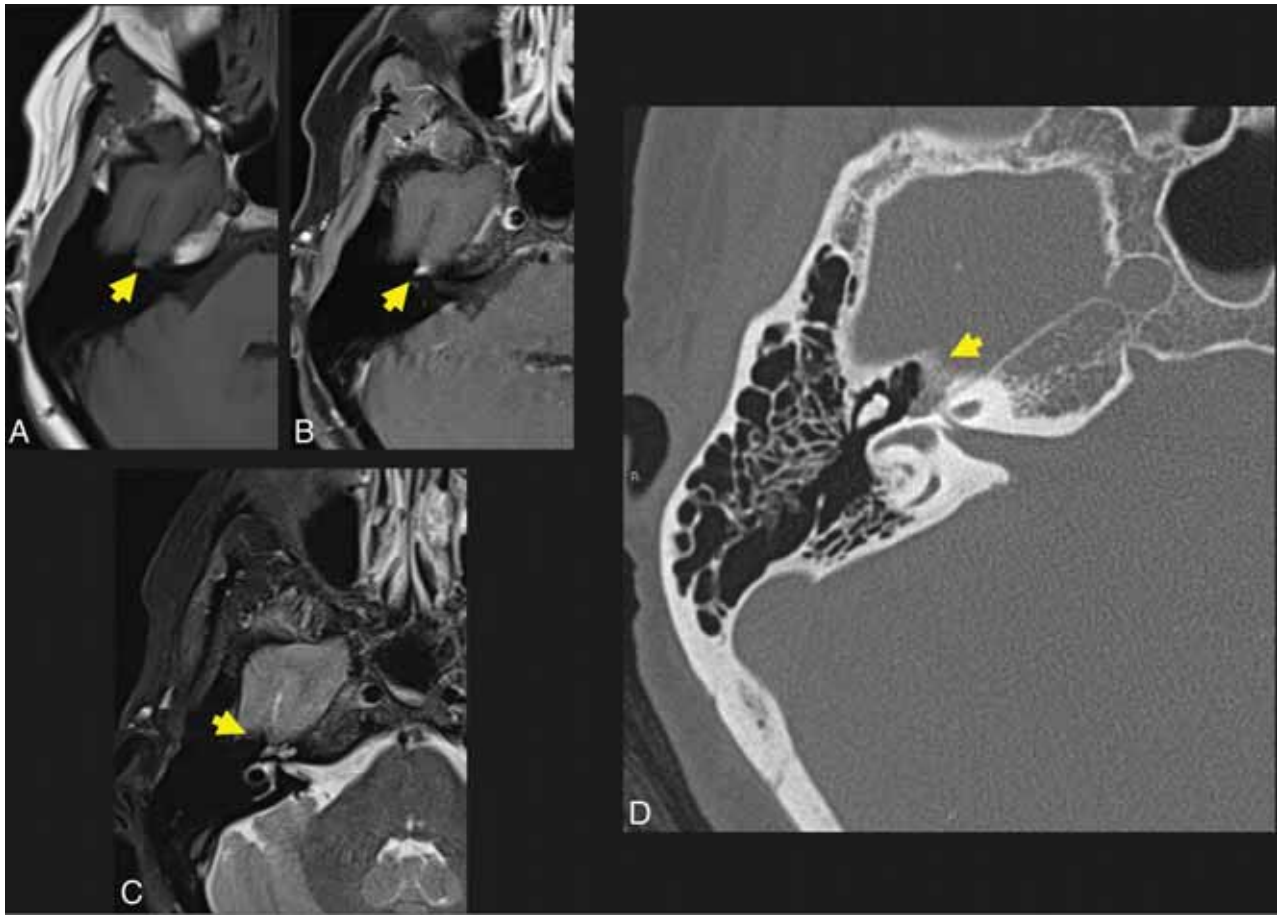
A 57-year-old woman who presented with right facial synkinesis. Noncontrast T1WI (A) and contrast-enhanced T1WI (B) demonstrate an enhancing lesion centered at the level of the right FN hiatus (yellow arrow, A and B), with corresponding increased signal on T2WI (C, yellow arrow indicates lesion). Differential considerations included both schwannoma and IOVM of the FN. Axial (D) thin-section CT of the temporal bone demonstrates an expansile, lucent lesion at the level of the anterior genu of the FN and FN hiatus (yellow arrow, D). The internal trabeculae help to confirm the diagnosis of IOVM because schwannoma would be less likely to show internal calcification. The diagnosis of IOVM was confirmed on pathology.
